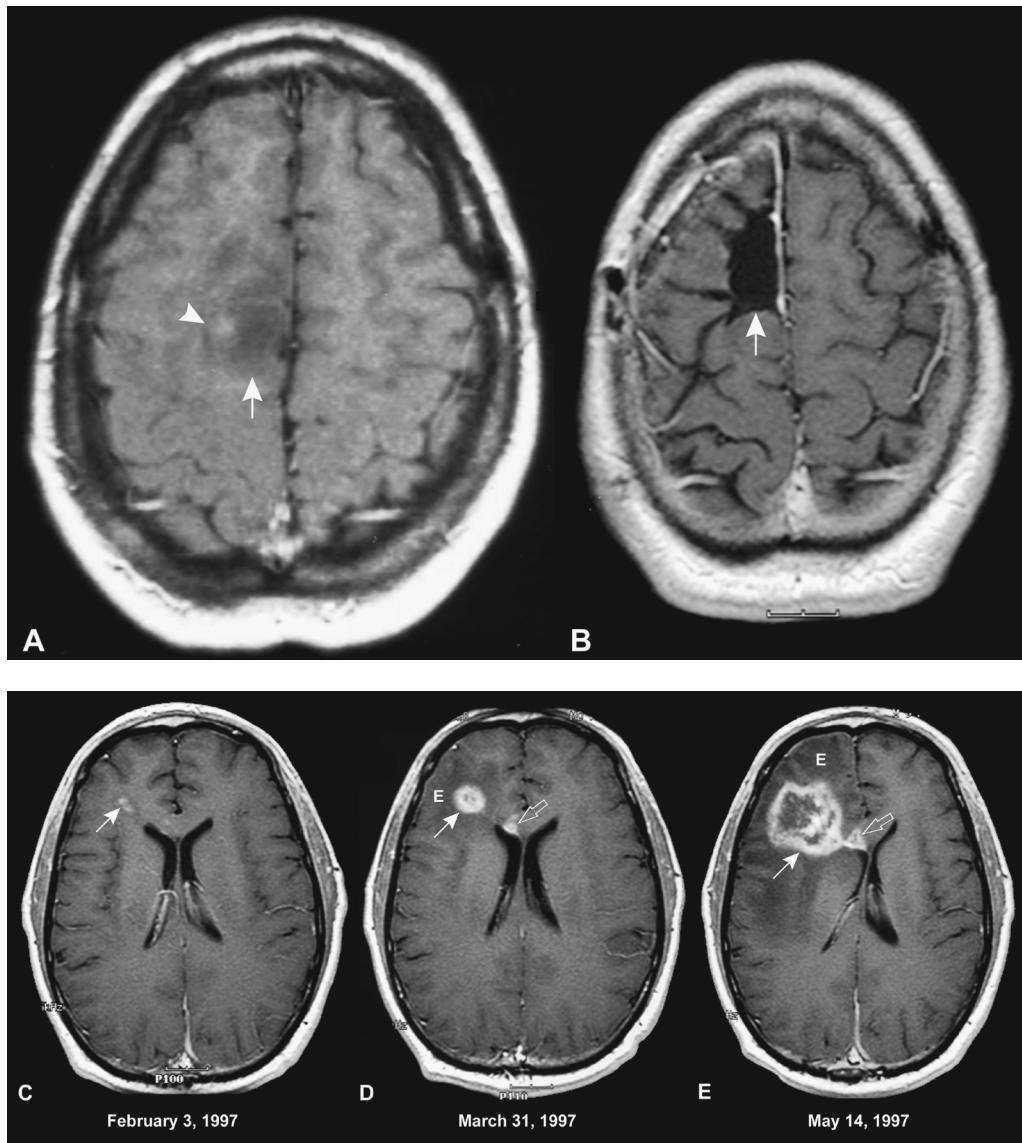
Post-contrast MR images (A-E). A nonenhancing tumor (arrow) with an enhancing nodule (arrowhead) occupying the right frontal lobe high-convexity region was noted in a 29-year-old male (A). The tumor was resected (resection cavity is shown in B, arrow). The tumor was an oligodendroglioma, and the patient was treated with radiation therapy (RT) and chemotherapy. The patient developed a small enhancing lesion in the right frontal lobe 8 months after completion of RT (arrow in C) that progressively increased in size in follow-up studies (arrows in D and E). There is also a progressive increase in the degree of edema (E) and mass effect on the right lateral ventricle. Surgical excision of the mass at this point revealed extensive radiation necrosis. Radiation necrosis affecting the corpus callosum is also shown (open arrows in D and E). Note that the radiation necrosis within the right frontal lobe (C-E) occurred remotely from the primary tumor (A).
